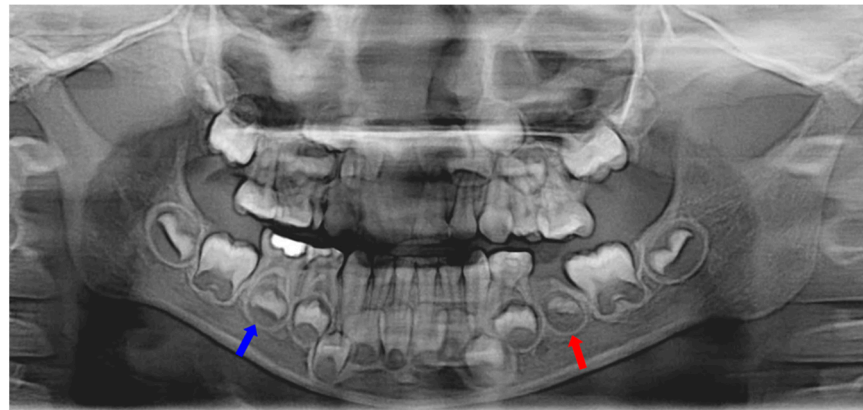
Eleven months after tooth extraction. Panoramic radiograph. The underdevelopment of the left mandibular second premolar tooth germ (red arrow) was observed compared with the opposite one (blue arrow).
